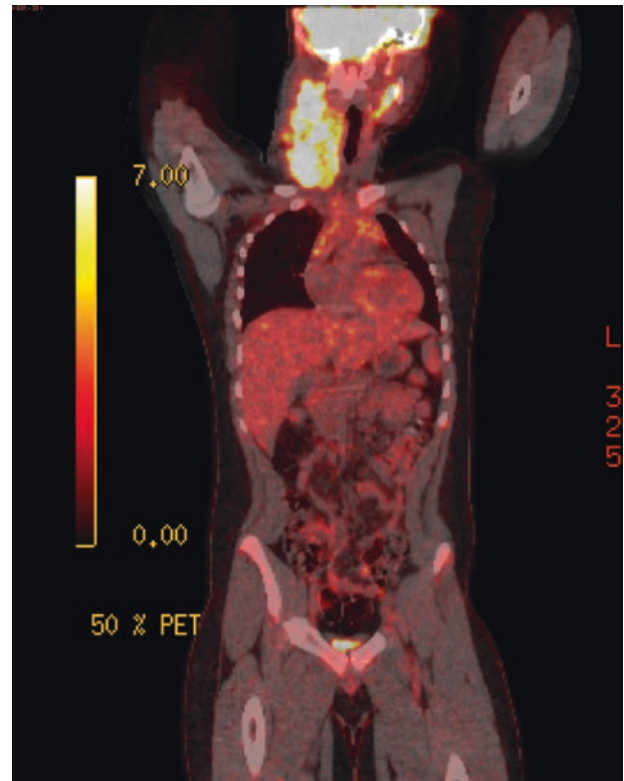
Lymphoma. Coronal PET-CT image shows avid uptake of ¹⁸F-FDG in the right cervical lymph nodes and a smaller area of uptake in the left cervical chain
